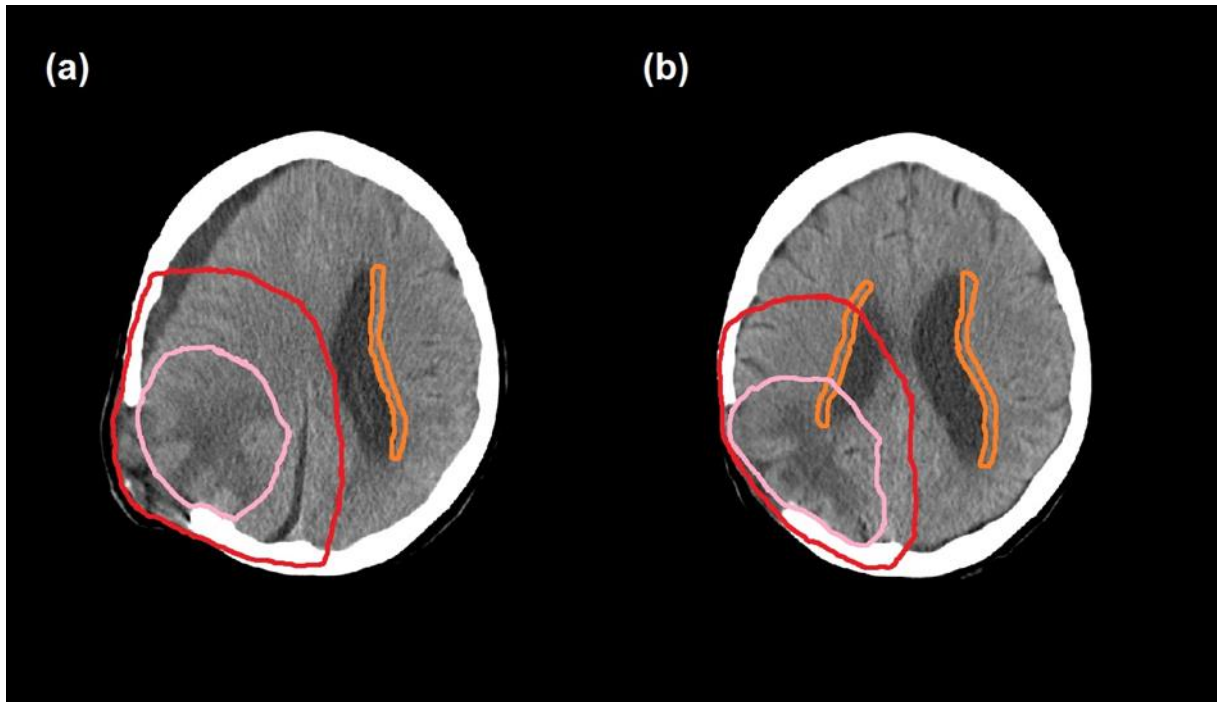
Initial (primary) CT (CT1) (a) and follow-up (secondary) CT (CT2) (b) with the contours for planning target volume (PTV) in red, gross tumor volume (GTV) in pink and subventricular zone (SVZ) in orange. Although the two images were captured on the same plane, initially the ipsilateral structures are extremely deformed and thus undetectable. After 40 Gy irradiation, the ipsilateral lateral ventricle and SVZ appeared on CT2.
